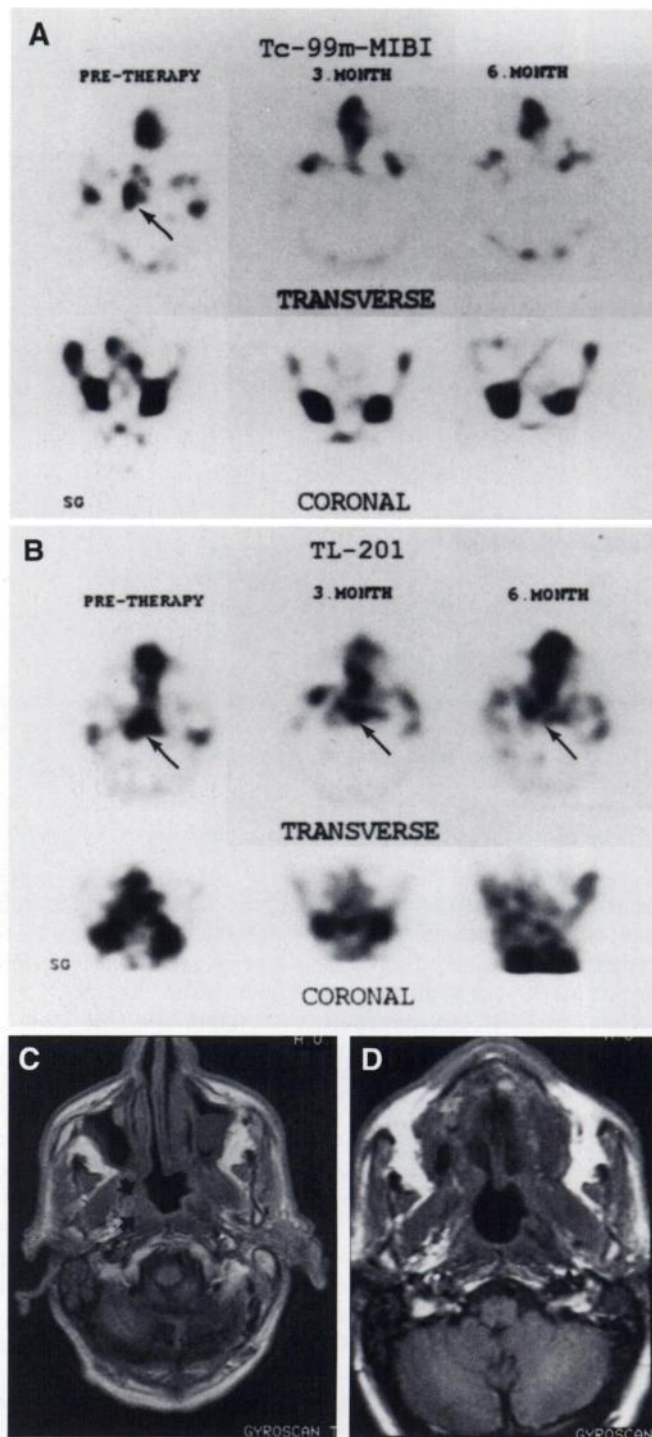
(A) Transverse (upper panels) and coronal slices (lower panels) of MIBI-SPECT studies performed before therapy (left column) demonstrate increased radiotracer uptake in the right pharyngeal recess (arrow) consistent with NPC. After therapy, 3- and 6-mo SPECT studies (middle and right columns, respectively) show no appreciable uptake in the same region consistent with complete response to therapy. (B) Transverse (upper panels) and coronal slices (lower panels) of ²⁰¹Tl SPECT studies performed before therapy (left column) depict increased radiotracer uptake in the right pharyngeal recess (arrow) corresponding to the uptake seen on MIBI-SPECT study. After therapy, 3- and 6-mo ²⁰¹Tl SPECT studies (middle and right columns, respectively) reveal low-grade increased uptake in the same region consistent with residual NPC. (C) MRI study of the nasopharynx performed 3 mo after therapy reveals a mass located in the right pharyngeal recess (arrows) consistent with residual disease. Endoscopic/physical examination was negative for residual disease. (D) MRI study of the nasopharynx performed 6 mo after therapy does not demonstrate any residual mass in the nasopharynx. Endoscopic/physical examination was negative for residual disease. Twelve months after completion of therapy, the patient was endoscopically and clinically free of disease.
